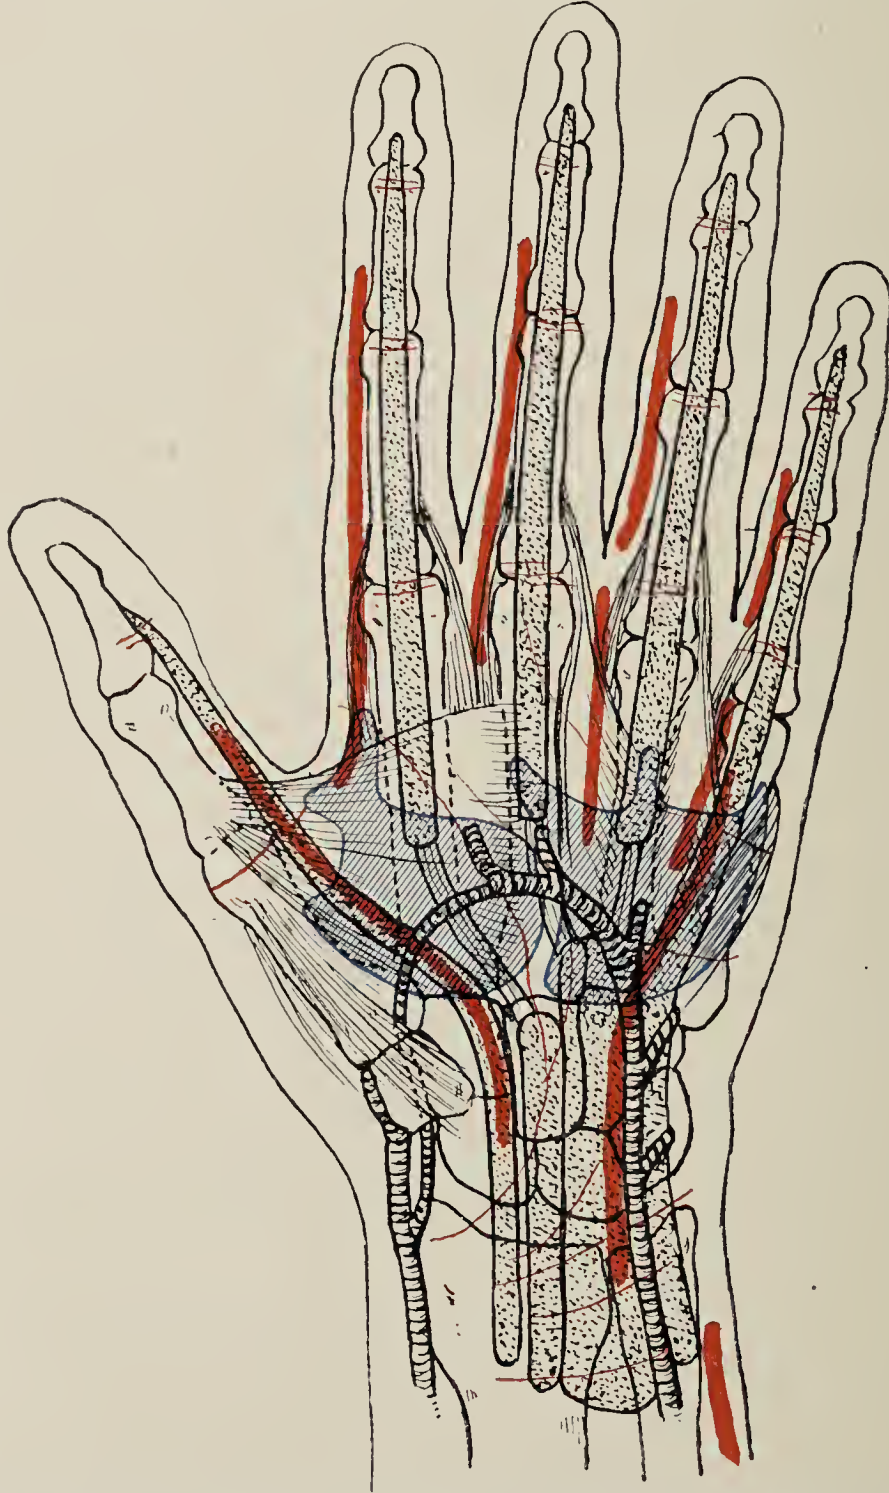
PALMAR ASPECT OF HAND, SHOWING TENDON-SHEATHS, PALMAR SPACES (blue), AND LINES OF INCISION AND FLEXION CREASES (red).
